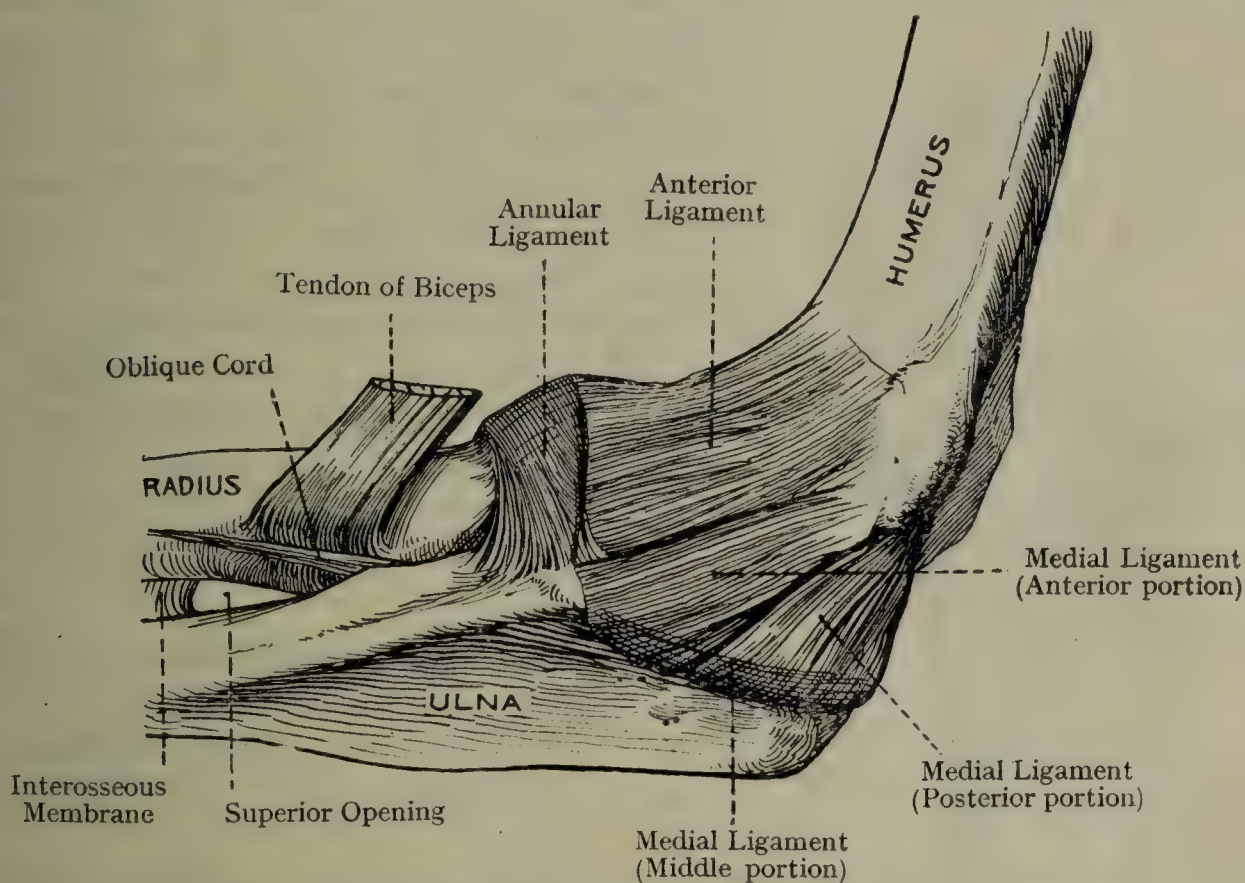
THE RIGHT ELBOW-JOINT (MEDIAL ASPECT).
